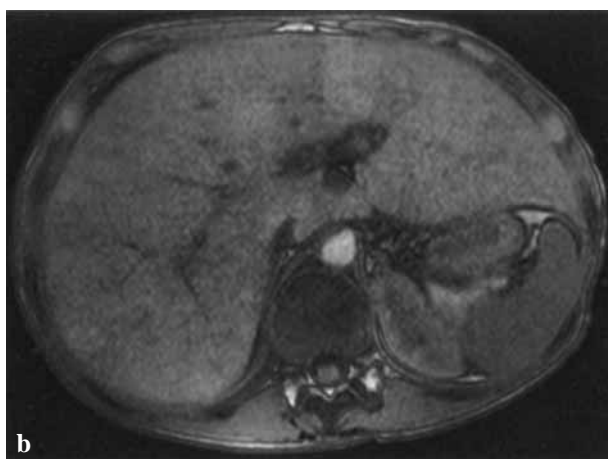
(a) Coronal MR angiographic image shows hepatomegaly, ascites, right pleural effusion, and the confluence of patent hepatic veins with inferior vena cava. T1-weighted gradient-echo images before (b) and after (c) injection of a gadolinium chelate show patchy hepatic enhancement, suggestive of sinusoidal congestion, and central bright spots corresponding to patent branches of hepatic veins.
